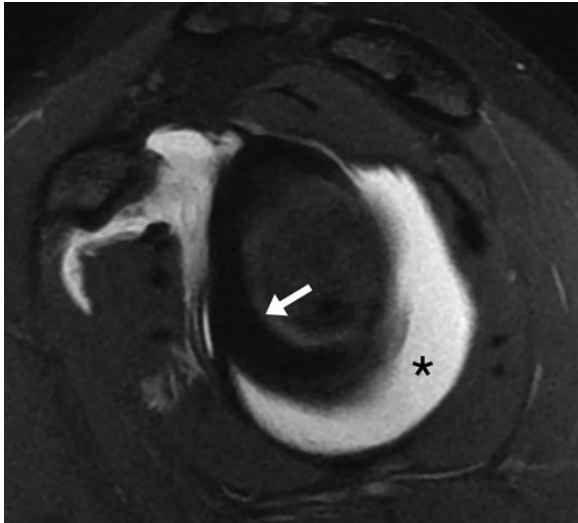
Sagittal T2-weighted, fat-saturated magnetic resonance image with arthrogram demonstrating intact circumferential labrum (arrow) with capacious capsule evident posterior and inferior (asterisk). Image courtesy of SD Peds Ortho.
